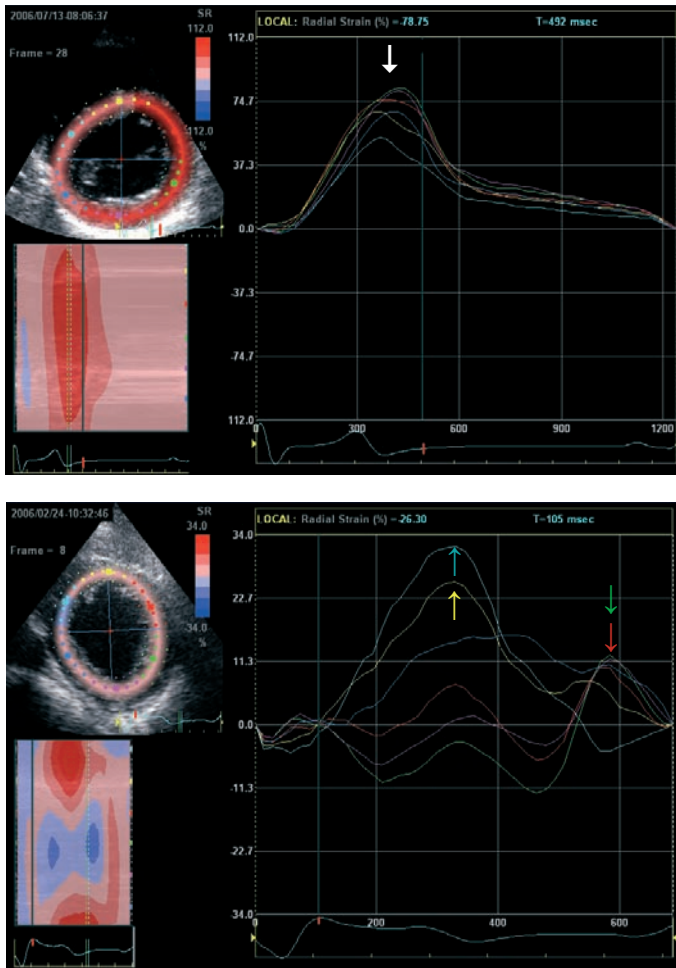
Panel A: Speckle tracking derived radial strain imaging in the parasternal short-axis view at the mid LV level. In this example peak radial strain (arrow) occurs simultaneously in all 6 segments, indicating a synchronous LV contraction (the curves are color-coded in accordance with the segments on the short-axis view). Panel B: Example of radial time-strain curves from speckle tracking in a heart failure patient with LV dyssynchrony. The septal regions reach peak strain early in systole (blue/yellow curves), whereas the lateral segments reach peak strain late in systole (red/green curves, arrows indicate peak systolic strain).
